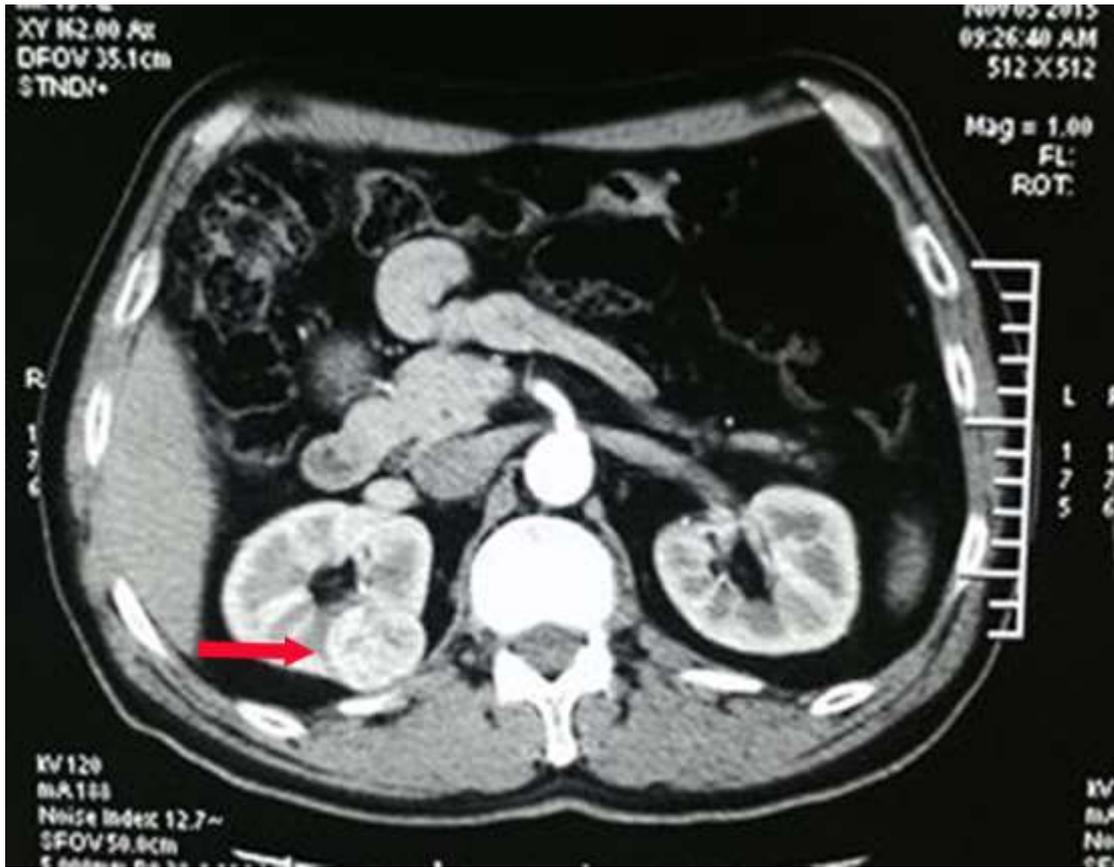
Abdominal CT shows a regular halo surrounding a renal neoplasm.
